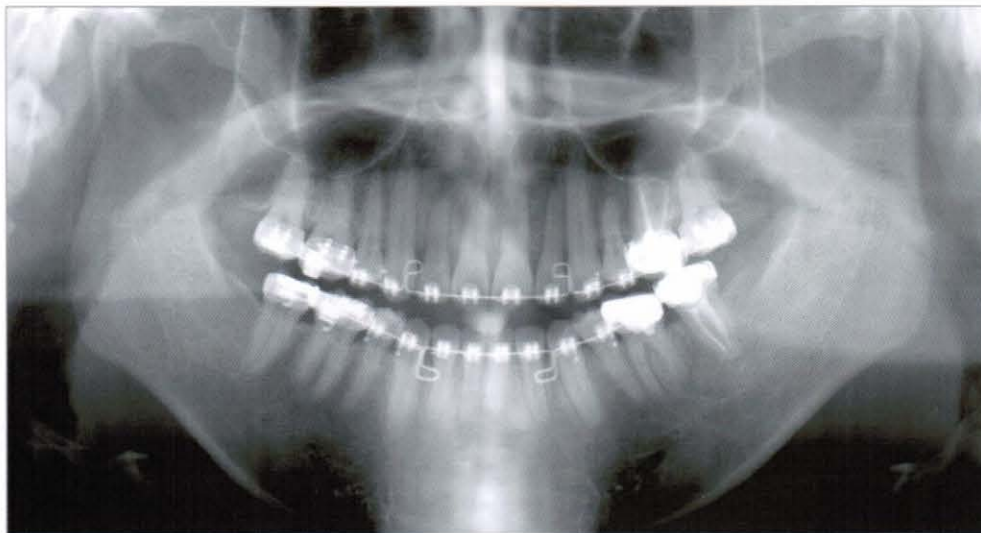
Panoramic radiograph at completion of space closure (2005, 4,19)
